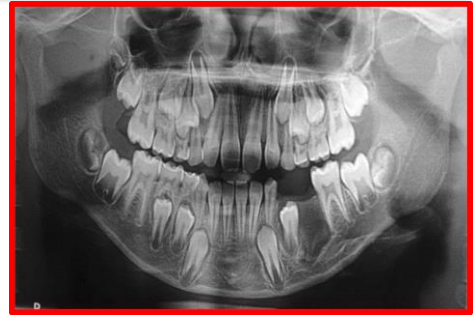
One year post-operative panoramic radiograph showing the healed surgical defect following enucleation of the lesion and extraction of 74, 75 and 35
